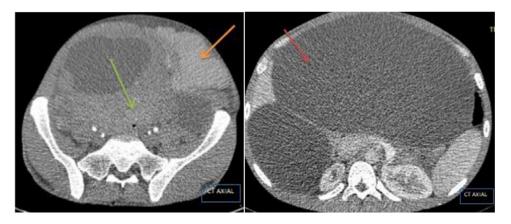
Axial CT scans depict the voluminous intra-abdominal mass with its dual components and the inguinal mass.
